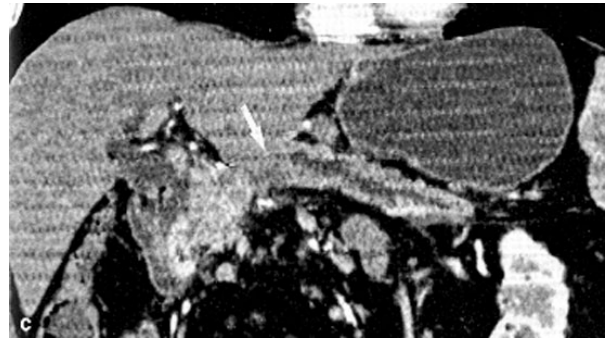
Multidetector computed tomography scan: small pancreatic cancer in a patient with mild acute pancreatitis.
